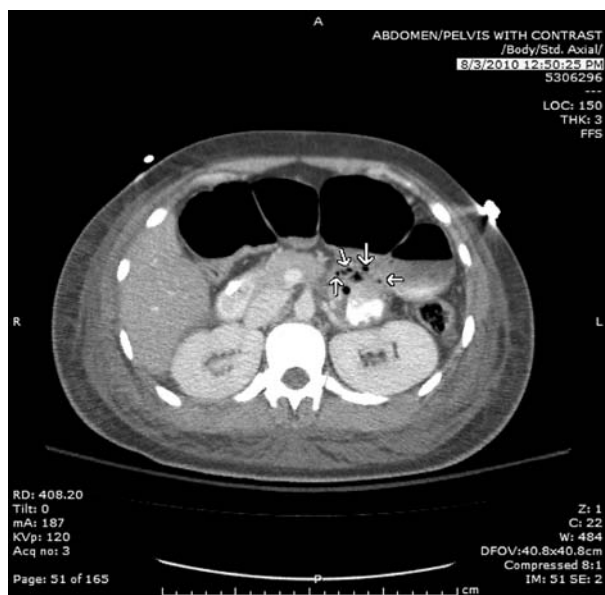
Computed tomography scan of the abdomen demonstrating a pneumointestinalis (arrows)
